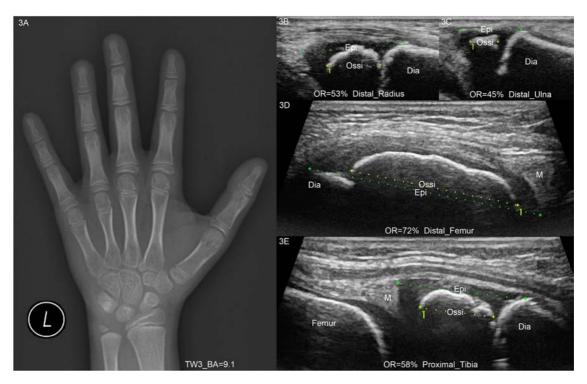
(a) Radiograph of left hand and wrist. (b-e) Sonographic findings for the distal radius (b), ulna (c), the medial epicondyle of the femur (d) and medial tibial condyle (e) of a 9-y-old girl. Radiographic bone age was 9.1 y after interpreted with TW3 for Chinese population. *The dotted line* represents the measurement of the diameters of the epiphysis and ossification center. OR = ossification ratio defined as the ratio of the ossification center and epiphysis diameters; Epi = epiphysis; Ossi = ossification center; Dia = diaphysis; M = meniscus.
